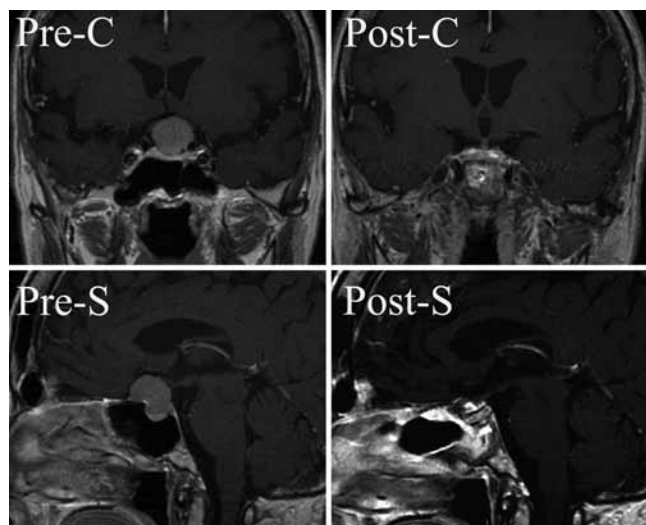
Case 1. Preoperative (left) and postoperative (right) T1-weighted contrast-enhanced coronal (upper) and sagittal (lower) MR images demonstrating a complete resection and the typical postoperative appearance.
